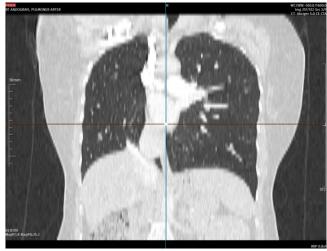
Patient's thorax CT parenchyma images showing the mediastinal structures displaced to the right. Evaluation of the sections in the lung parenchyma window revealing reduced right hemithorax volume
